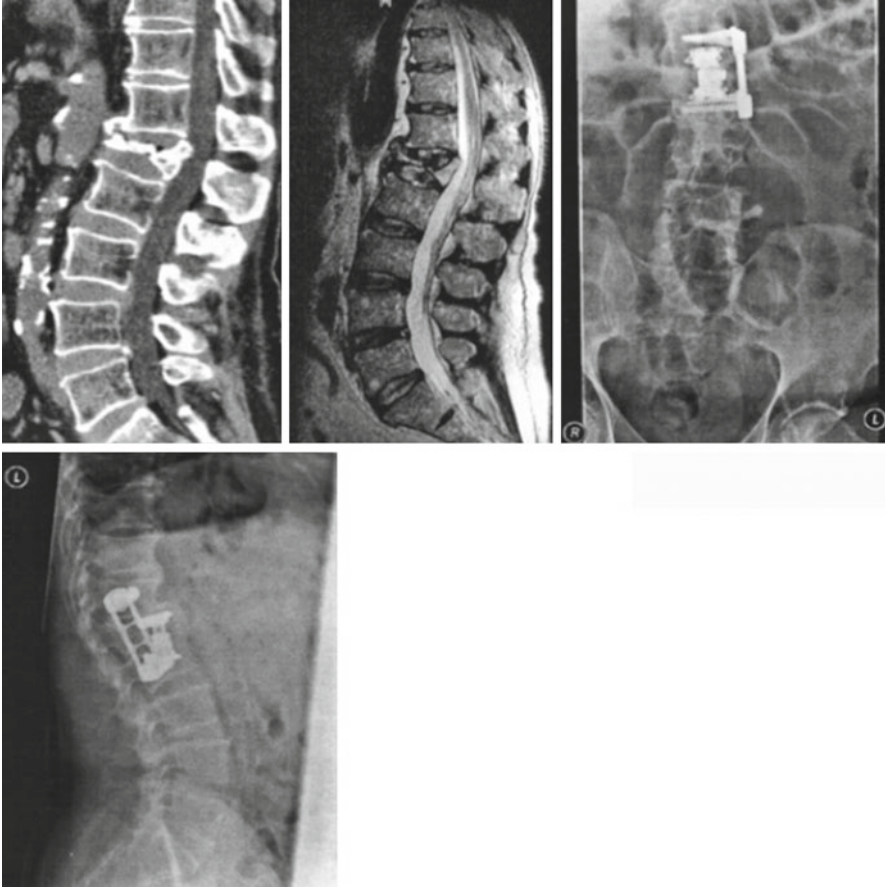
Magnetic resonance imaging showing an unstable fracture of L1 with an internal gibbus, treated by internal fixation with correction of the internal gibbus (Courtesy of Dushyant H. Thakkar, London, UK. Reproduced with kind permission of Springer Verlag)
